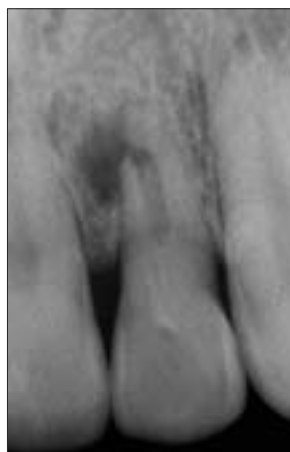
Outcome classified as "disease." Pre-operative radiograph of a maxillary lateral incisor with apical periodontitis.
